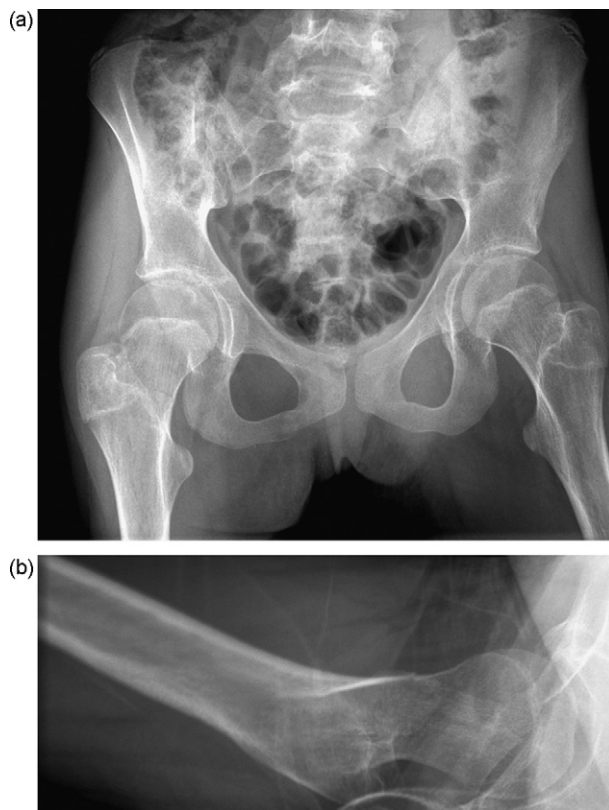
(a) Pre-operative antero-posterior radiograph of patient's pelvis and (b) pre-operative lateral radiograph of patient's right hip.
